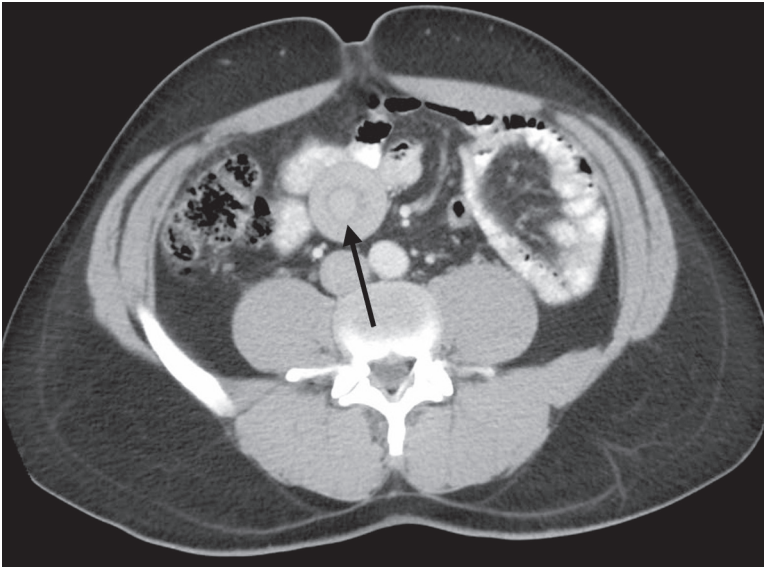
CT Scan of intussusception
